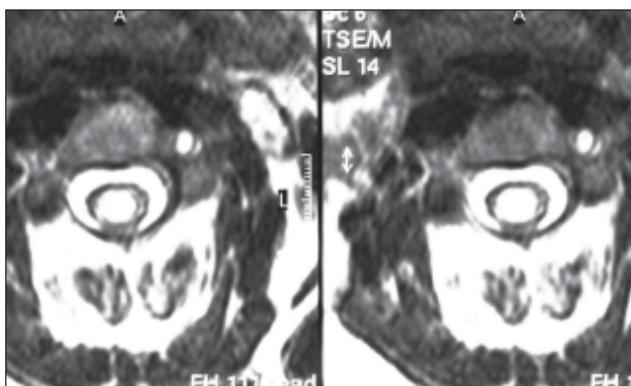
MRI of cervical spine – transversal section
